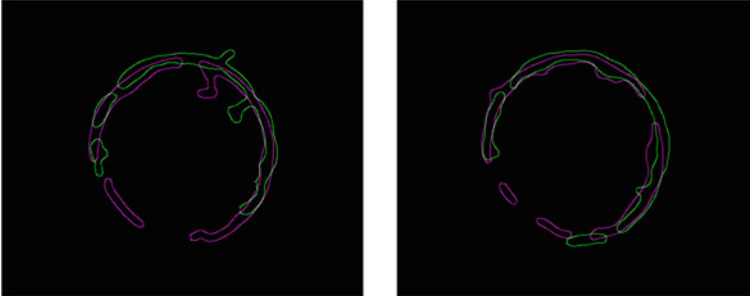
Samples of overlaying wall edges detected from CT and MRI. Green = CT and magenta = MRI
